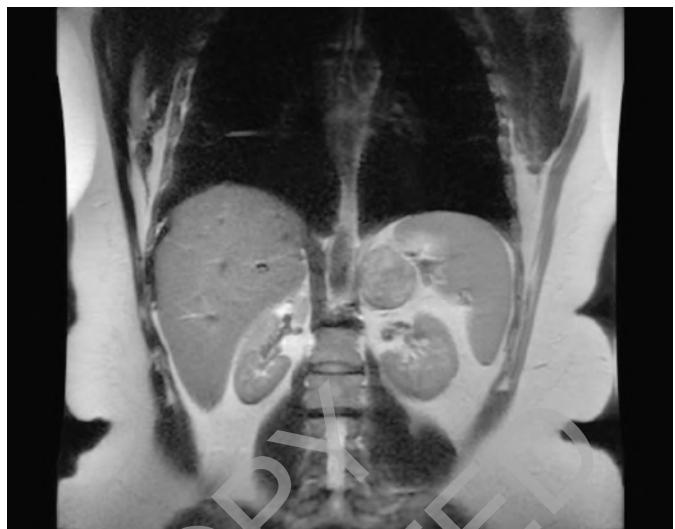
MRI scan of left adrenal mass.
